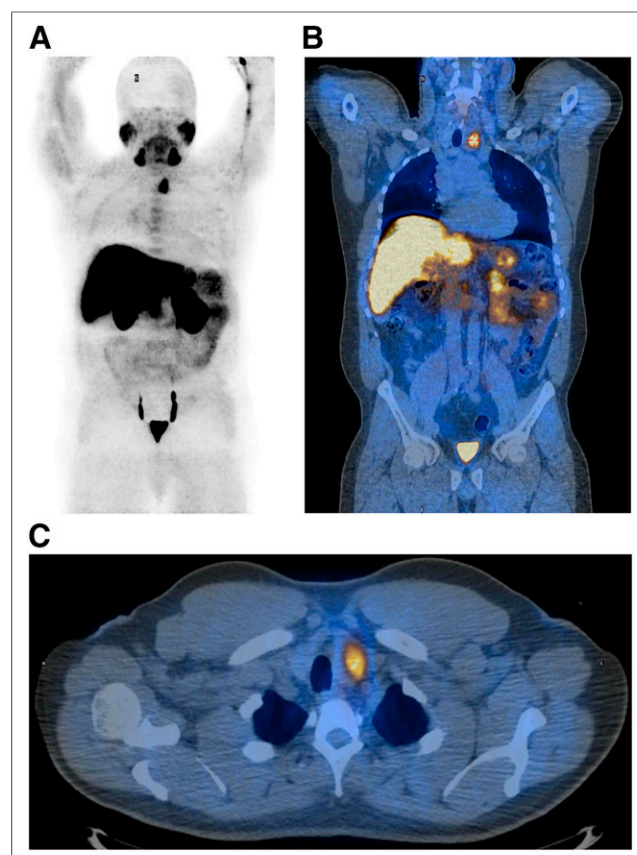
Maximum-intensity-projection (A) and fused ^{18}F -fluorocholine PET/CT images in coronal (B) and transaxial (C) views show focus of high uptake in left thyroid nodule.
